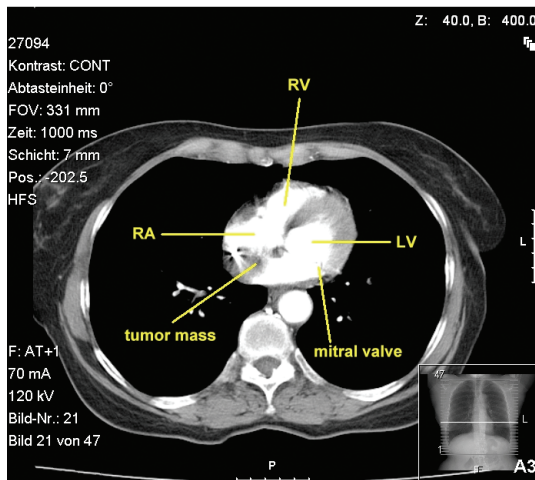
Transversal computed tomography of the cardiac hibernoma. RA indicates right atrium; RV, right ventricle; LV, left ventricle.
